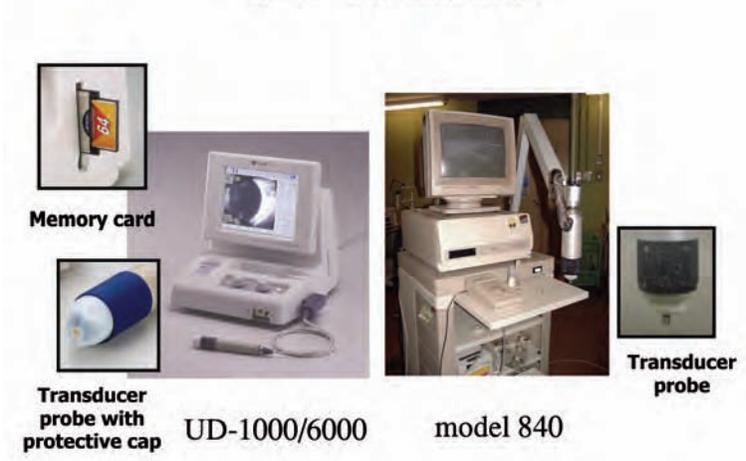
Left: UD-1000/6000 ultrasound machine and UD-6010 probe. A protective cap covers the probe tip. Right: Model 840 conventional UBM machine and probe.
